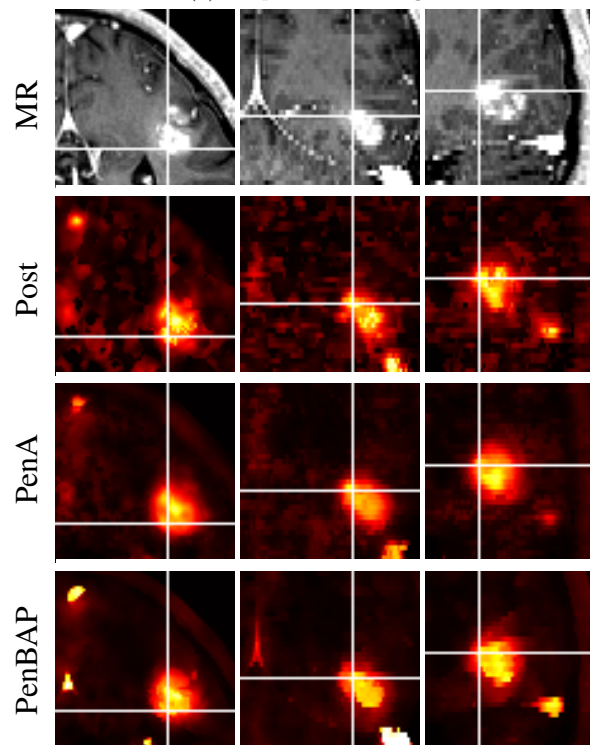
A section of the brain from Figure 4.11 showing the lesion with the corresponding MR image. Transverse, sagittal, and coronal views are shown in columns.
